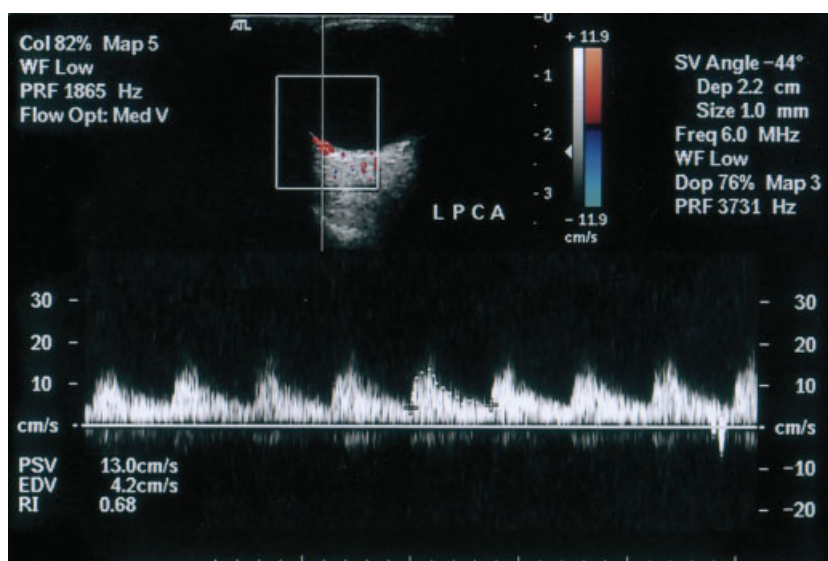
Color duplex sonogram of a lateral posterior ciliary artery (LPCA) in a patient with obstructive sleep apnea syndrome shows a peak systolic velocity (PSV) of 13.0 cm/second and a resistance index (RI) of 0.68.
